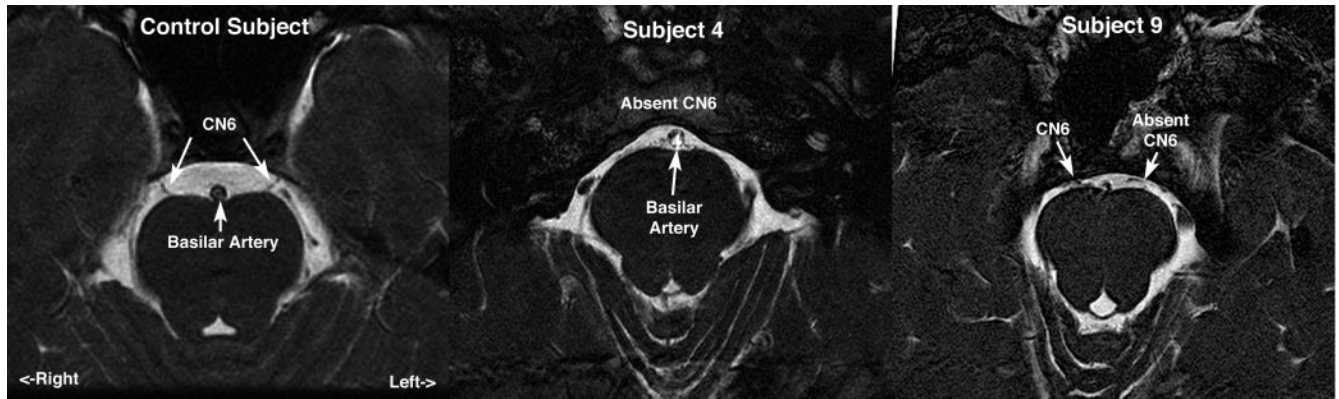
Oblique, axial, heavily T_2 -weighted MR images showing at *left* the normal course of the abducens nerve (CN6 dark) from the pons highlighted against the bright signal of the surrounding cerebrospinal fluid. In contrast, the CN6s of subject 4 with DURS2 appeared absent and the left CN6 of subject 9 was shown to be absent by the identical technique. In each panel, CN6 was demonstrated in the optimal 1-mm-thick image plane in which it appeared or was expected to appear based on surrounding landmarks.
